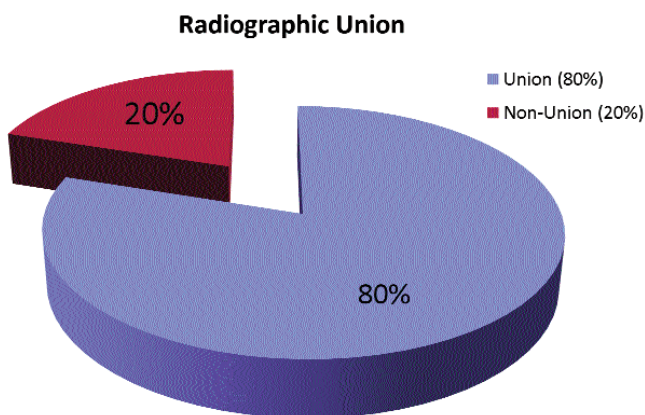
Radiographic Union rates.
